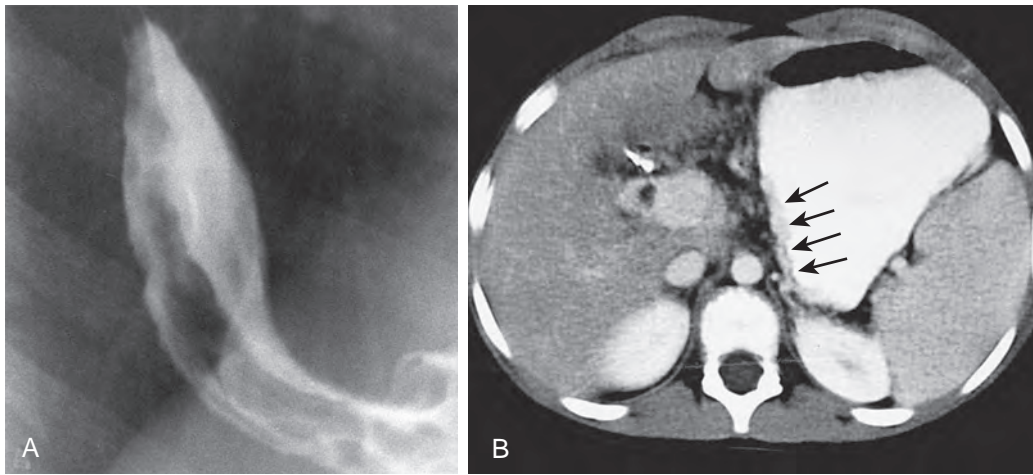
Esophageal varices. A. Barium esophagogram. A spot film of the esophagogastric junction demonstrates a large, linear varix. B. CT scan shows varices (arrows) along the posterior and medial aspects of the fluid-filled stomach.
